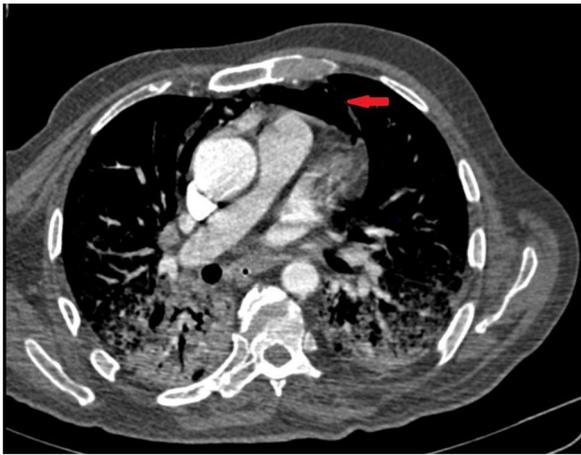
Chest CT scan showed diffuse bilateral ground-glass opacities with isolated pneumopericardium (Red arrow).
